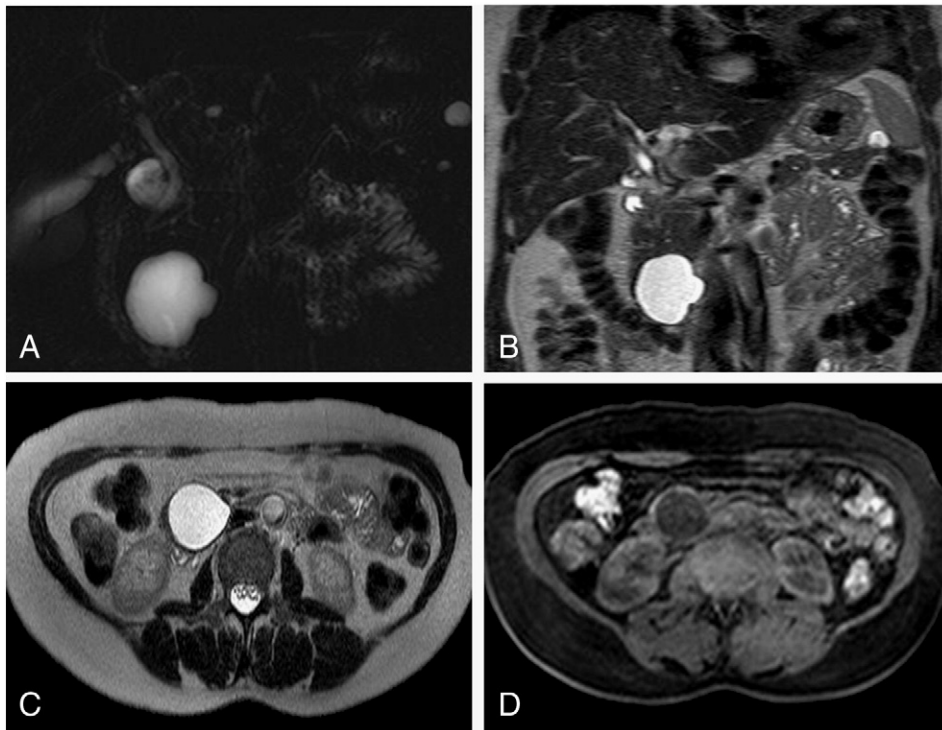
MR imaging performed three months later demonstrated size stability of pancreatic cystic lesions. Coronal magnetic resonance cholangiopancreatography (MRCP; A), coronal (B) and axial (C) T2-weighted MR images and axial unenhanced fat-suppressed T1-weighted (D) MR images. Despite maintaining high signal intensity on T2-weighted MR sequences, the cystic fluid had become hypointense on T1-weighted MR sequences suggesting a simple fluid appearance.
